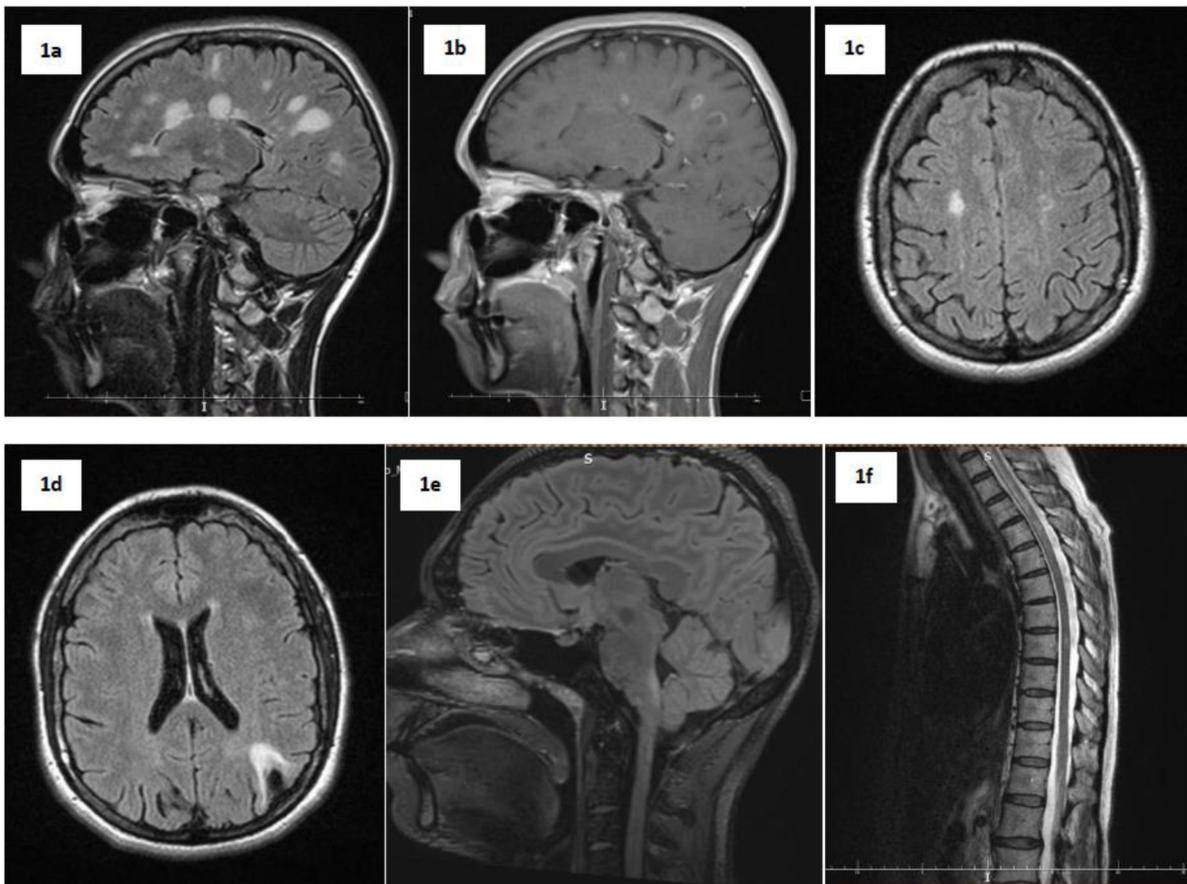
Different types of white matter lesions in CNS inflammatory diseases. (a). Typical MRI findings in MS: T2-hyperintense periventricular and juxtacortical lesions. (b). T1 scan showing ring and open ring gadolinium enhancement pattern of lesions present in Fig.1a. (c). Subcortical FLAIR-hyperintense white matter lesions in a patient with APS secondary to SLE. (d). Cortical-subcortical malacia after an ischaemic stroke in the same patient with APS secondary to SLE presented in fig. 1c. (e). T2 dark fluid-hyperintense lesion in area postrema in a patient with SLE which needs to be differentiated from NMOSD. (f). Diffuse T2-hyperintense lesion at the level Th1 to Th4 affecting white as well as gray matter of spinal cord in NMO patient. Small T2-hyperintense lesions visible also at the level of Th8 and Th10.
